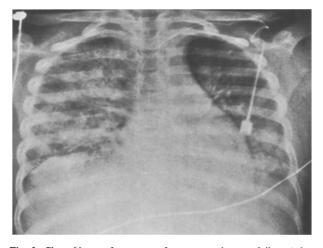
Chest X-ray after onset of severe respiratory failure (after thoracentesis)
